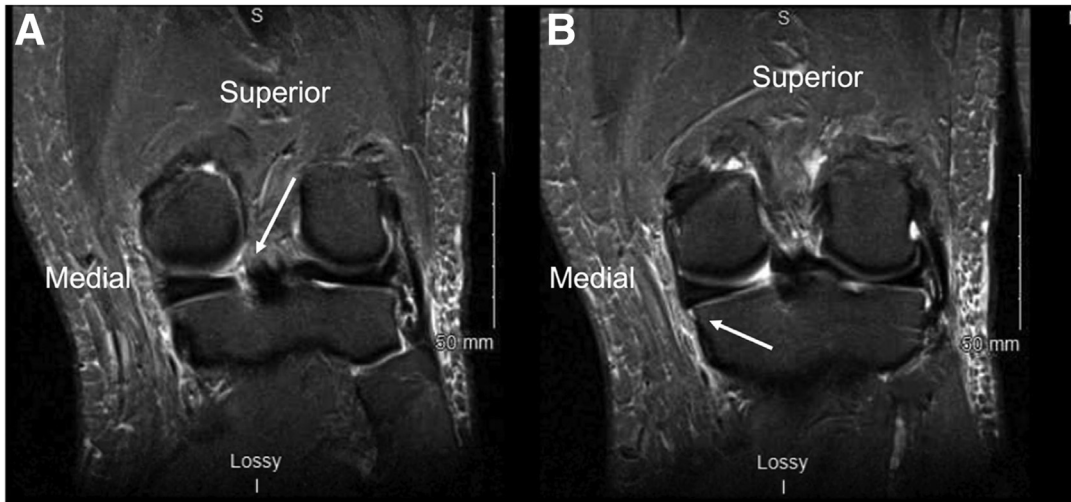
T2-weighted coronal MRI images demonstrating a posterior root medial meniscus tear (white arrow) (A), as well as associated meniscal extrusion (white arrow) (B).
